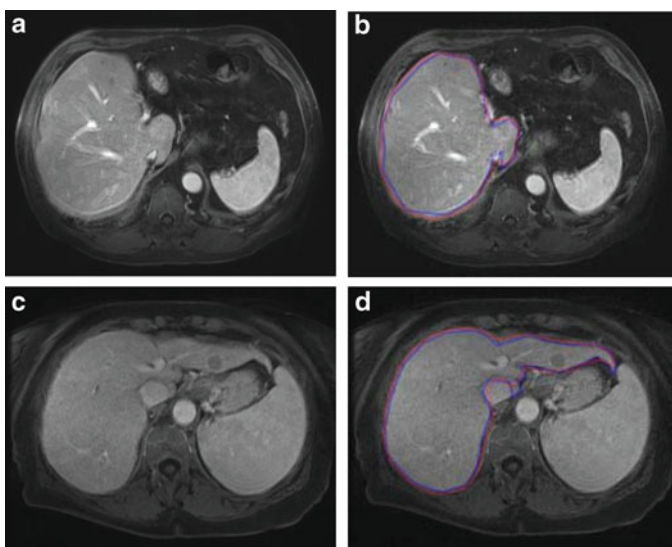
Comparisons of the computerized liver extraction with “gold-standard” manual liver extraction for two cases with accuracies (99.5 % for the upper case; 99.2 % for lower case) close to the average accuracy (99.4 %). (a) Original axial MR image from one of the cases. (b) Corresponding computerized liver extraction (*red contour*) and “gold-standard” manual liver extraction (*blue contour*). (c) Original axial MR image from the other case. (d) Corresponding computerized liver extraction (*red contour*) and “gold-standard” manual liver extraction (*blue contour*)
